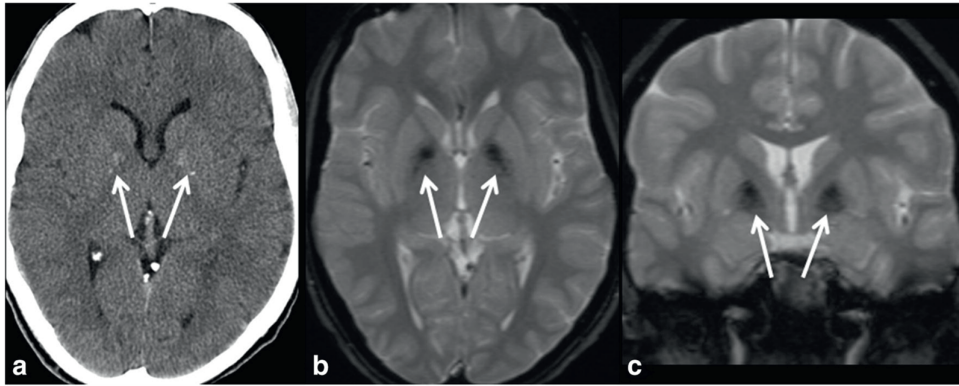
Brain CT (a) and T2 FFE MRI (b, c) of patient 1 at 29 years of age demonstrating calcifications in both globus pallidus (arrow); note the blooming effect on T2FFE.
